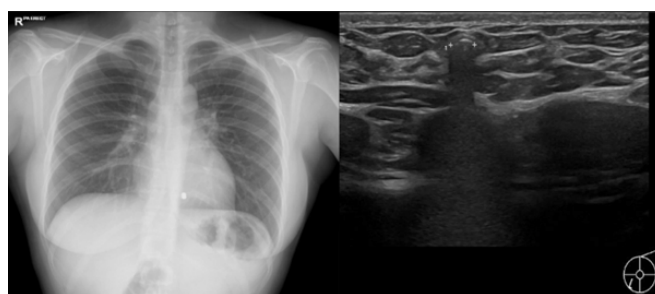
Chest radiograph (left) demonstrating a small, well-circumscribed radio-opaque density overlying the left breast, consistent with a retained airgun pellet. Ultrasound examination (right) shows a corresponding densely echogenic focus within the breast tissue with marked posterior acoustic shadowing, characteristic of metallic foreign body.
